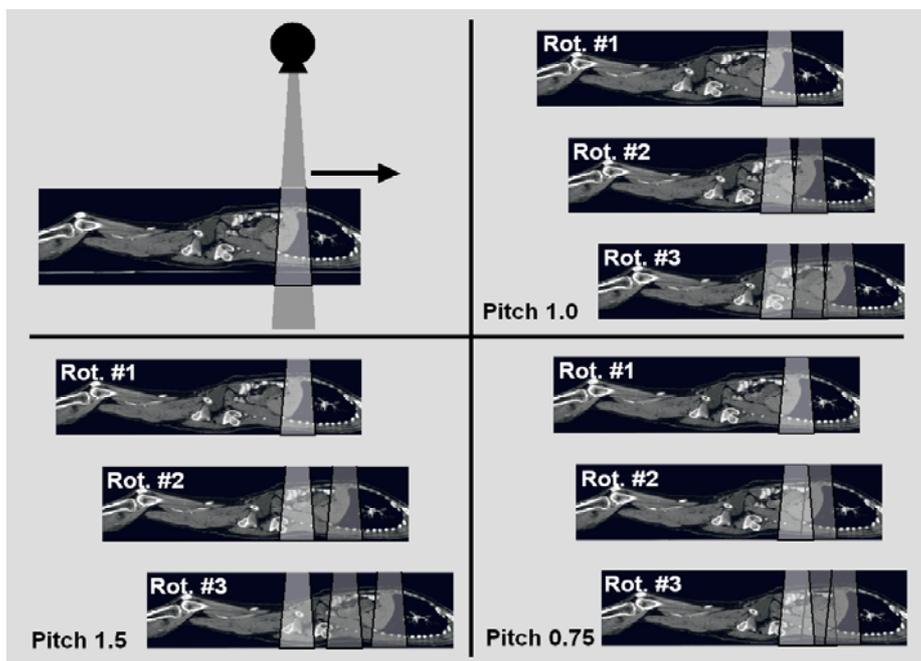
The figure shows the irradiated volume for three contiguous rotations at the moments with the x-ray tube in the frontal position. The table speed and the beam collimation determine the pitch factor. A high table speed introduces interspaces (e.g. pitch factor 1.5), a low table speed yields an overlapping acquisition (e.g. pitch factor 0.75). A pitch factor of 1.0 yields a contiguous acquisition. The arrow indicates the direction of the table speed.
